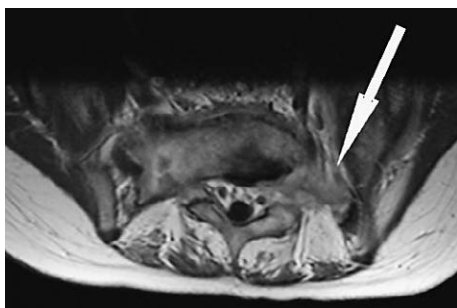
Postcontrast T1 MRI (S1)
